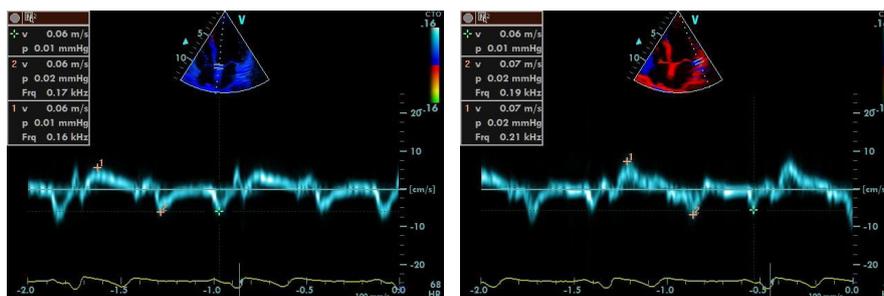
Pulsed Wave Tissue Doppler Imaging at the Level of the Septal (A) and Lateral (B) Mitral Annuli
